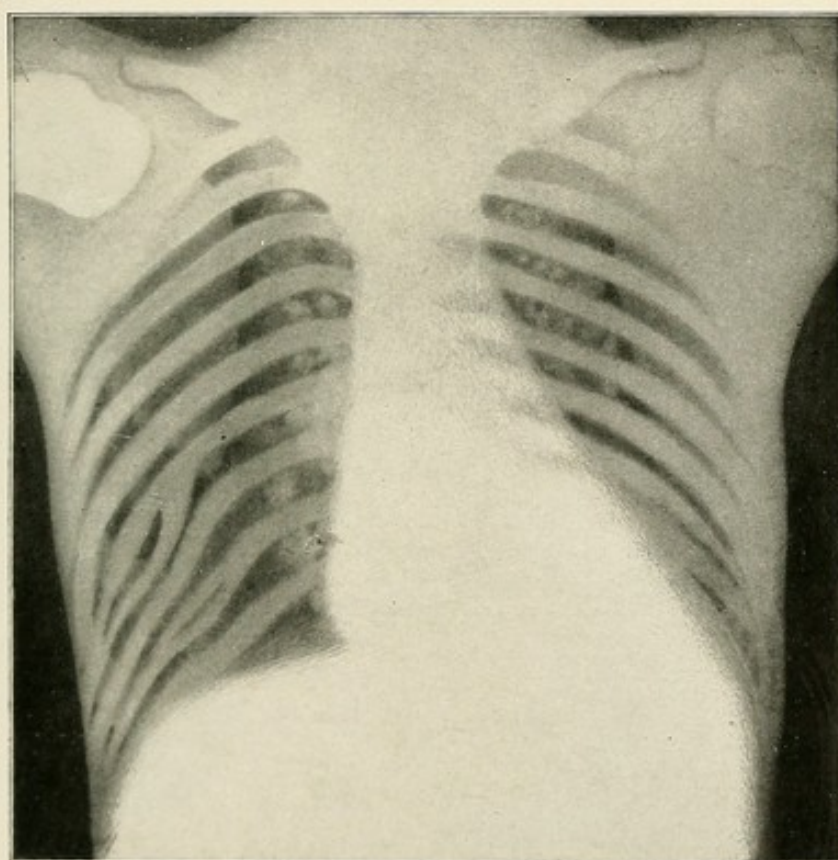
X-ray picture (re-touched), two years after extirpation of the left lower lobe (GARRE).
